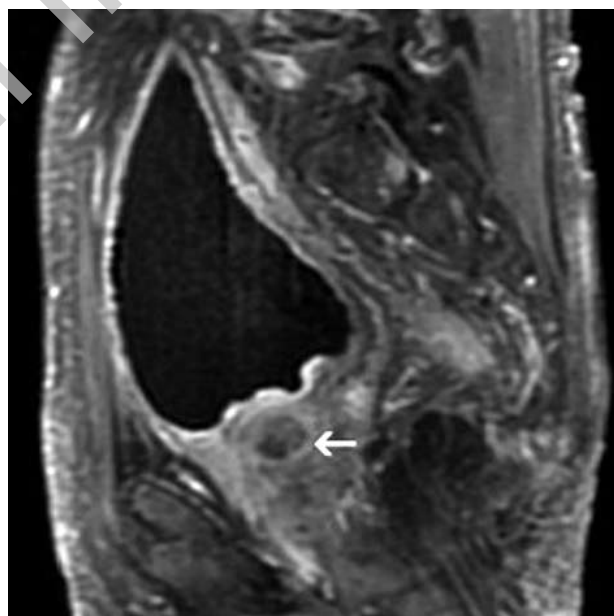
Sagittal contrast-enhanced T1-weighted MR image with fat saturation shows that the prostatic lesion is composed of an enhancing rim (arrow) and a non-enhancing, hypointense central part.
